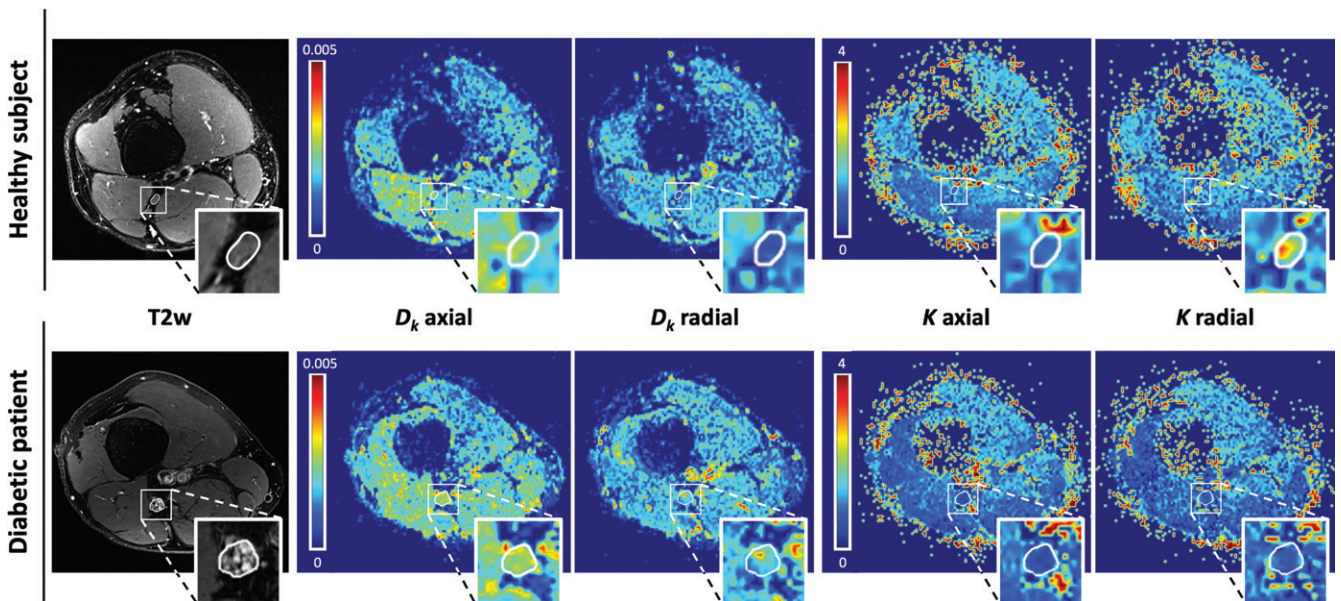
Representative T2-weighted (T2w) images of the distal sciatic nerve and corresponding color-coded parameter maps of D_k and K for axial and radial diffusion directions derived from the kurtosis model in a healthy volunteer (upper panel) and a patient with diabetes (participant 2 in Table 1) (lower panel). Segmentation of the tibial nerve portion is indicated by a white contour. Insets show magnification of the nerve. Compared with those in the healthy volunteer, higher D_k and lower K values can be seen in the participant with diabetes in the radial diffusional domain. D_k is in 10^{-3} mm²/sec.
